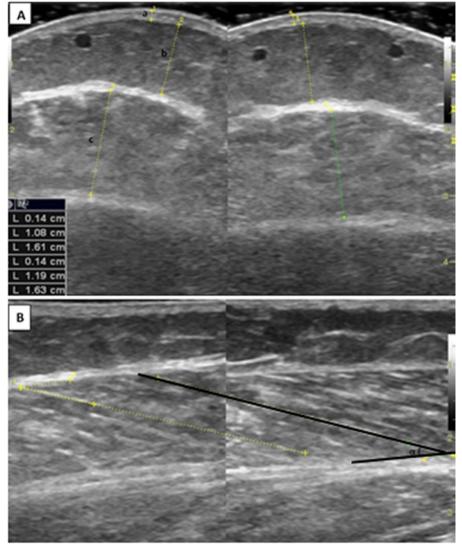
Comparative ultrasound imaging of the calf region.
